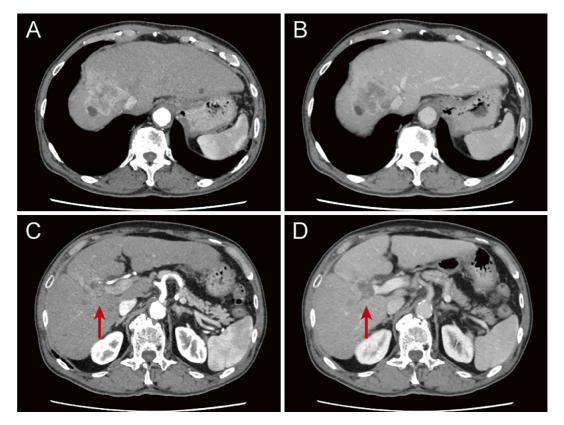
Contrast-enhanced computed tomography before initiating lenvatinib. An ill-defined heterogenous arterial phase hyperenhancement (A) and washout on portal phase (B) in the right lobe of the liver indicated hepatocellular carcinoma. The inferior side of the hypervascular tumor invaded the main right portal vein (C), which was depicted as a perfusion defect on portal phase (D) (arrow).
